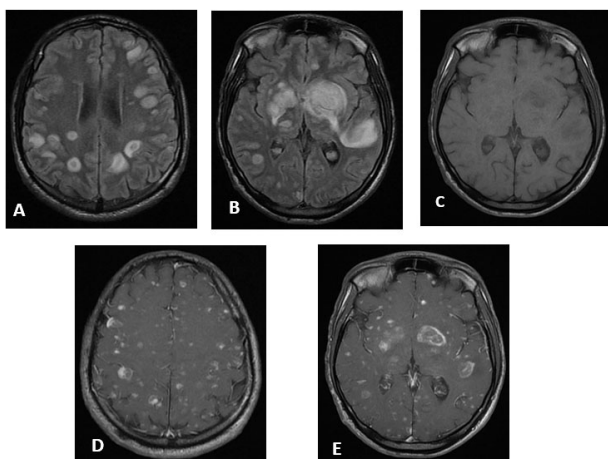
(A) to (E): Brain MRI exam showing in (A) and (B) axial FLAIR acquisition multiple hyperintense, diffuse, circumscribed parenchymal lesions, cortical and subcortical, in thalamus and capsule-lenticular, and bilateral. In (C), T1-weighted acquisition, larger lesions are hypointense, and after gadolinium in (D) and (E), it shows marked ring enhancement in larger lesions and nodular enhancement in small ones.
